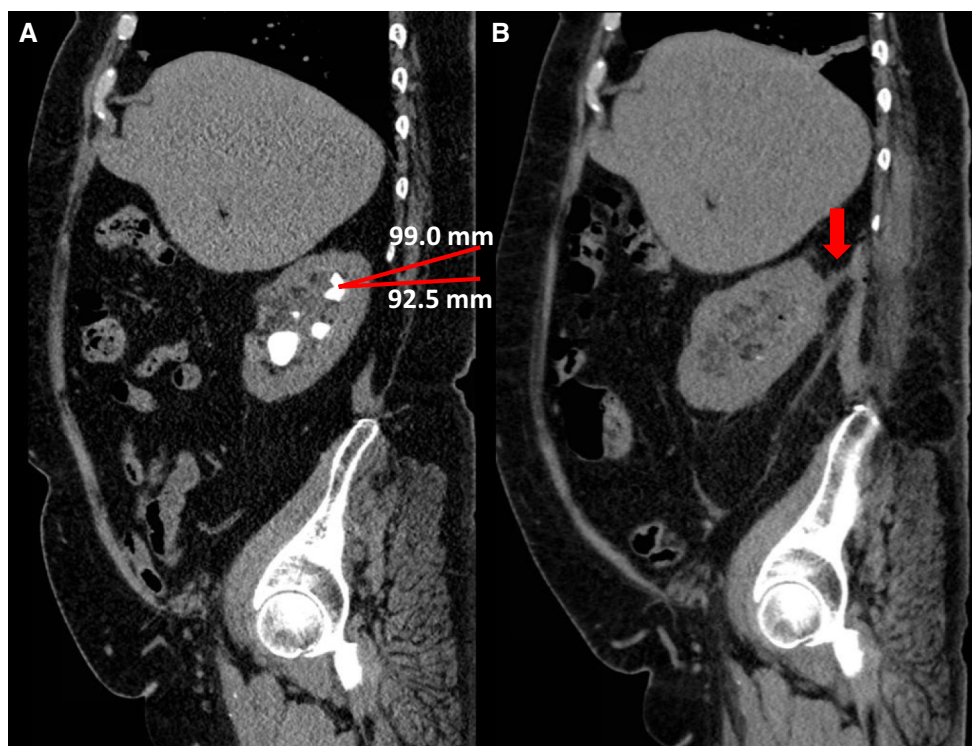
Sagittal a pre-operative nephrostomy tract length and b post-operative CT imaging of renal calculi showing the actual nephrostomy tract (red arrow)
